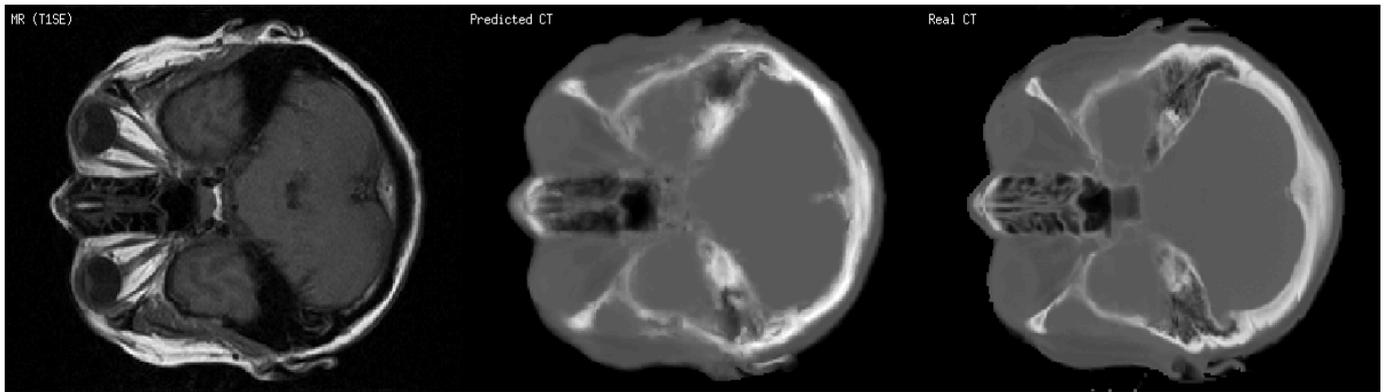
Left: The patient MR image. Middle: The “Pseudo-CT” as predicted using our method. Right: The real CT image.
